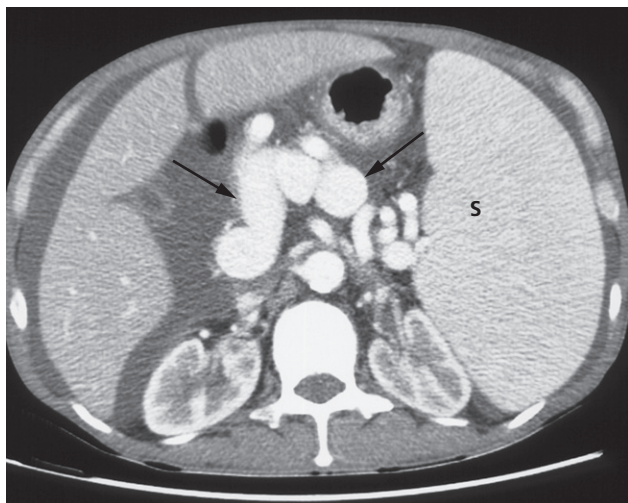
Varices on CT due to portal hypertension. There is marked enhancement of multiple serpiginous vessels in the upper abdomen (arrows), extending into the splenic hilum. There is splenomegaly and ascites. S, spleen.
